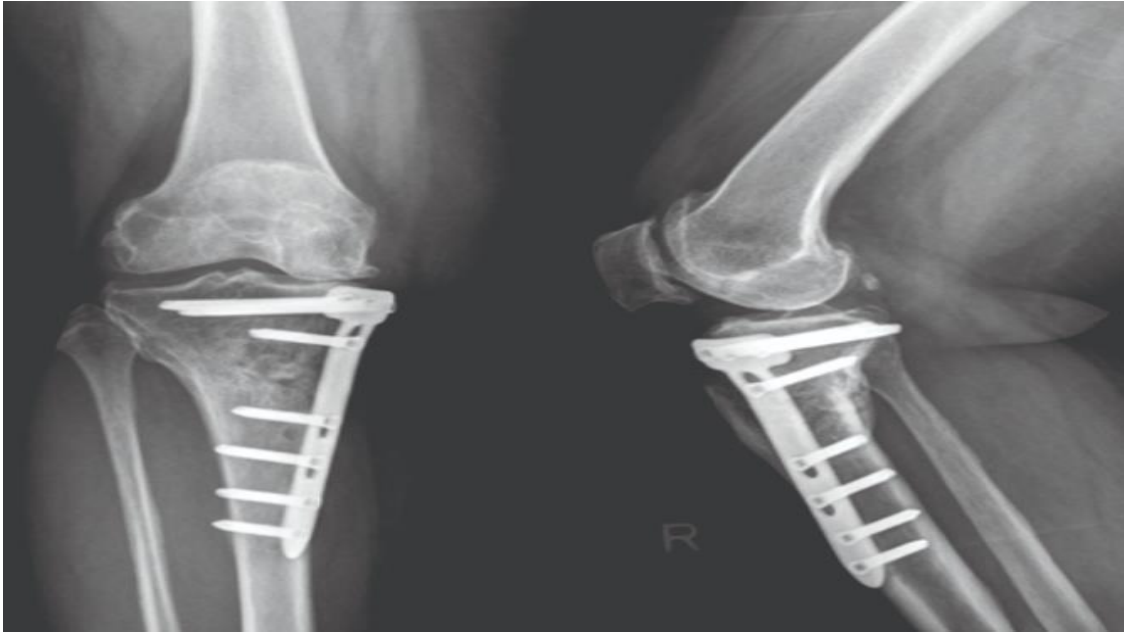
CT files of patients with arthritis after high tibial osteotomy (HTO)
